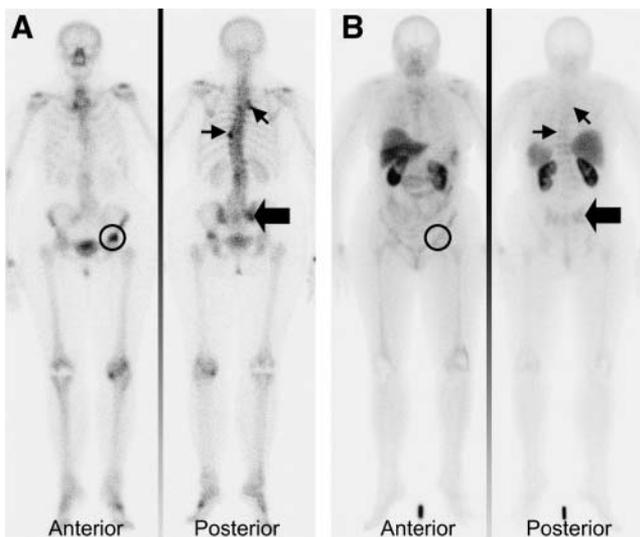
(A) 74-y-old woman (patient 1), under tamoxifen treatment, presented with positive bone scan showing multiple lesions in vertebral spine T3 and ribs, T9 (small arrows), right sacroiliac region (thick arrow), and left femur (circle). (B) ^{99m}Tc -depreotide scintigraphy, assessed before switch to second-line hormonal therapy, was negative. She was a nonresponder and the number of bone lesions increased.
